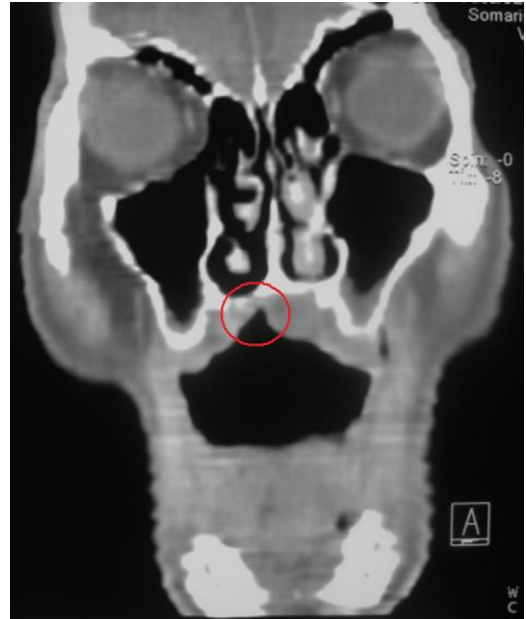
Computed tomogram. Coronal view showing the palatal destruction.
